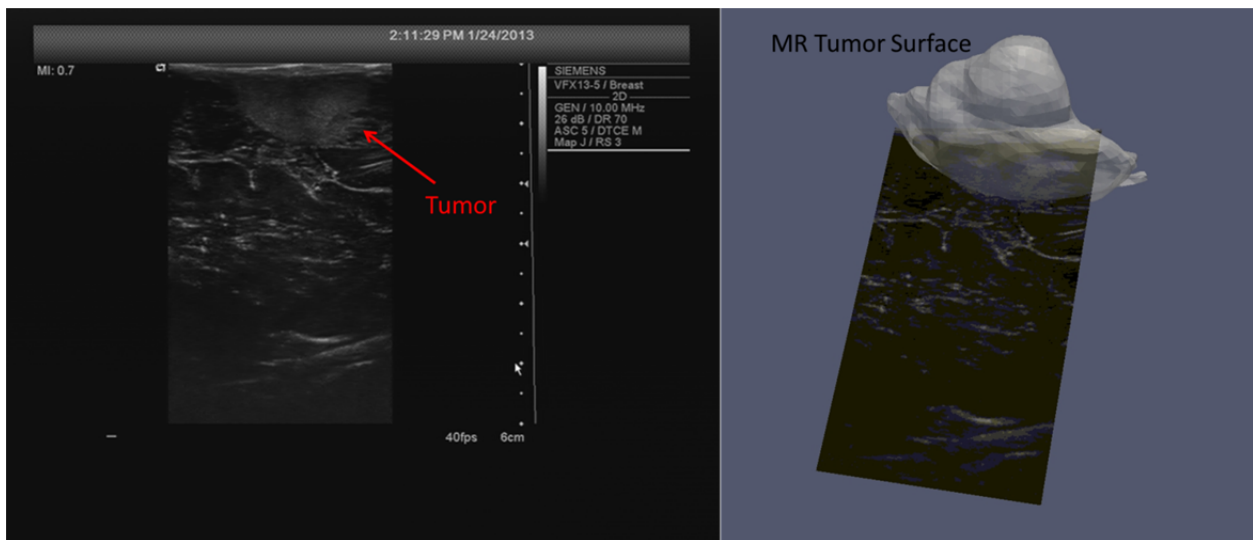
A B-mode image of the brain tumor (left), and the tracked ultrasound image in 3D space with the co-registered MR tumor (right).
